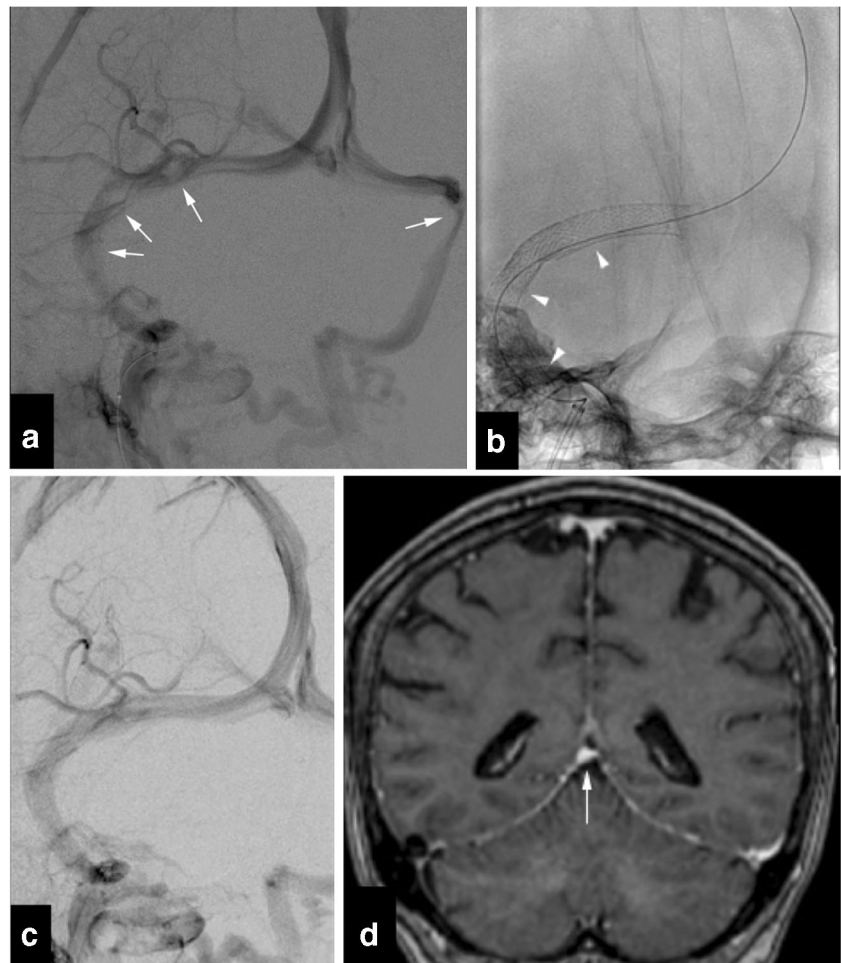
a–c DSA, left anterior oblique projections. d Gadolinium-3DT1 MPRAGE coronal plane reconstruction. a Venous phase of a right common carotid artery injection showing bilateral transverse sinus and right sigmoid sinus stenosis (arrows). b Two overlapping stents (arrowheads) are deployed in the distal two-thirds of the transverse sinus and sigmoid sinus on the right. c Venous phase of a right common carotid artery injection showing the right transverse and sigmoid sinus stenosis being relieved after stenting. d MRI 6 months after stenting showing resolution of abnormal pachymeningeal thickening and enhancement and normalization in size of the vein of Galen (arrow)—compared with pre-stenting MRI; Fig. 1a)
